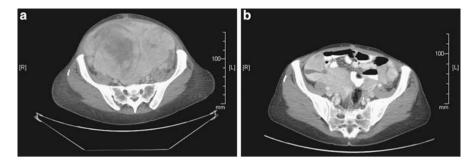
CT of malignant fibrous histiocytoma /undifferentiated pleomorphic sarcoma of abdomen (a), and response to treatment at 4 months (b)
